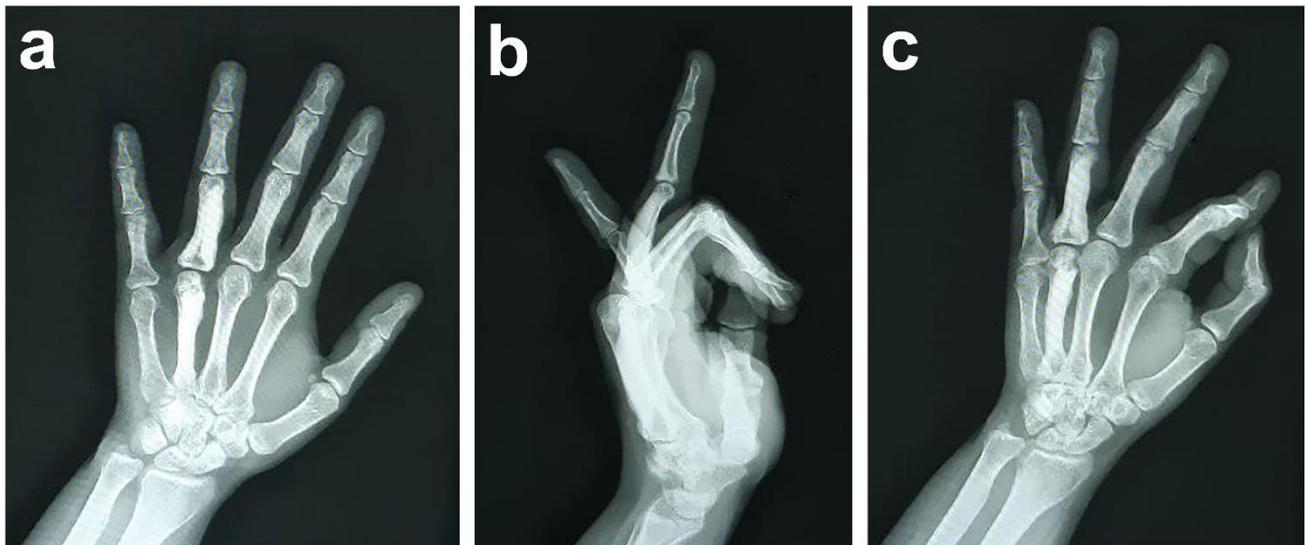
Plain radiography of the left hand after 5 years follow up. a: anteroposterior (AP) view; b: lateral view; c: oblique view.
